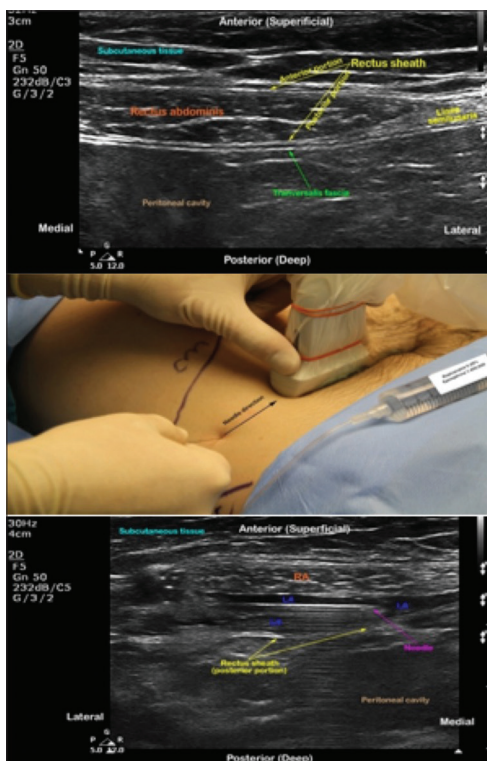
Ultrasound-guided rectus sheath block. Sonoanatomy, technique, and needle position shown in the upper, middle, and lower portion, respectively
